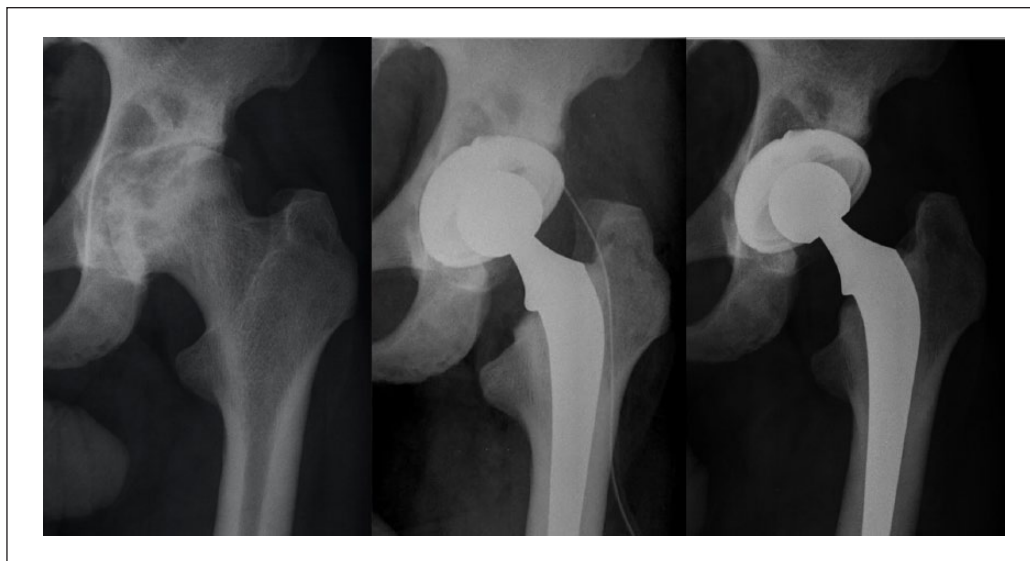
Cystic formation of the acetabulum on x-rays taken preoperatively and immediately postoperatively, and its persistence at the latest follow-up.
